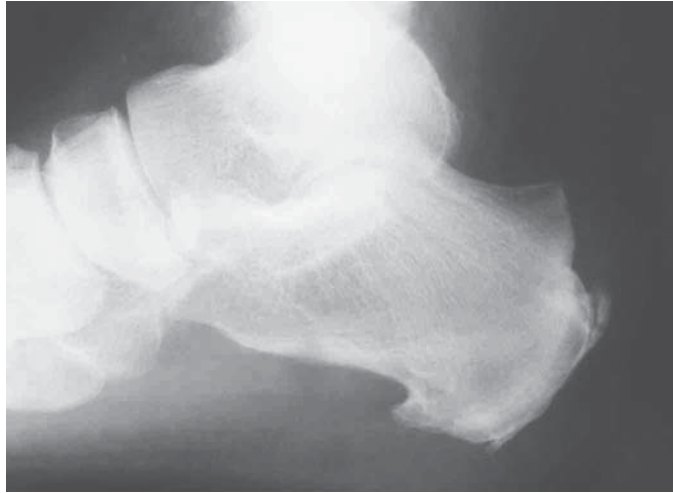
Plain radiograph demonstrating fishhook osteophyte and Haglund’s deformity.
